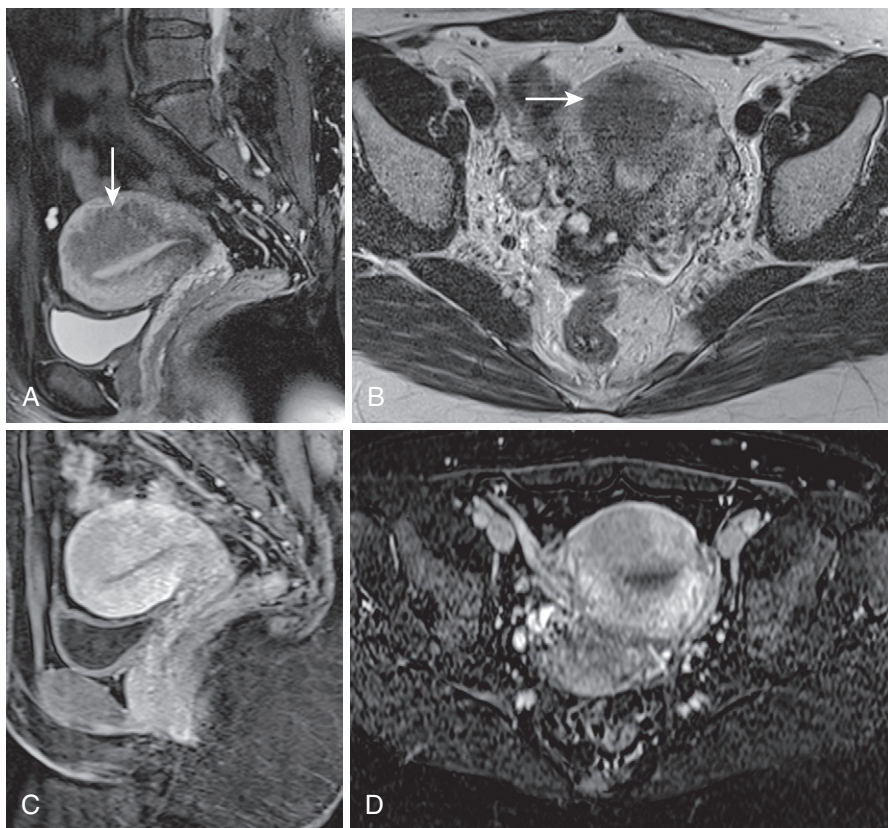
Focal adenomyoma. Sagittal (A) and axial (B) T2-weighted images reveal a lesion isointense to and blending with adjacent junctional zone with indistinct margins and exerting no significant mass effect on the underlying endometrium (*arrow*). Sagittal (C) and axial (D) enhanced T1-weighted gradient echo images with fat saturation confirm the inner myometrial origin.
